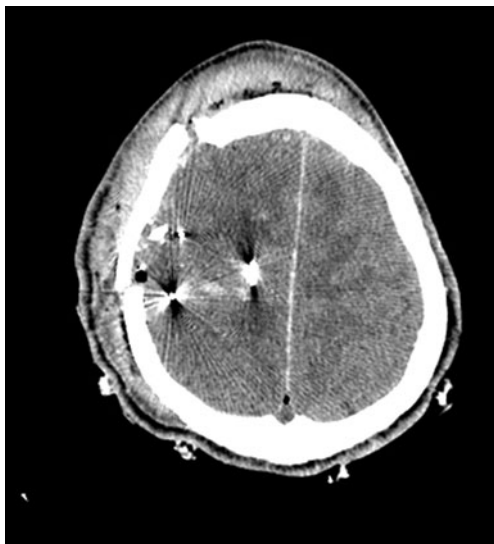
Axial noncontrast CT image demonstrates numerous ballistic and bone fragments with accompanying intra- and extra-axial hemorrhage and edema at the level of the right frontal and parietal lobes. An overlying calvarial fracture and extensive scalp swelling is also noted
